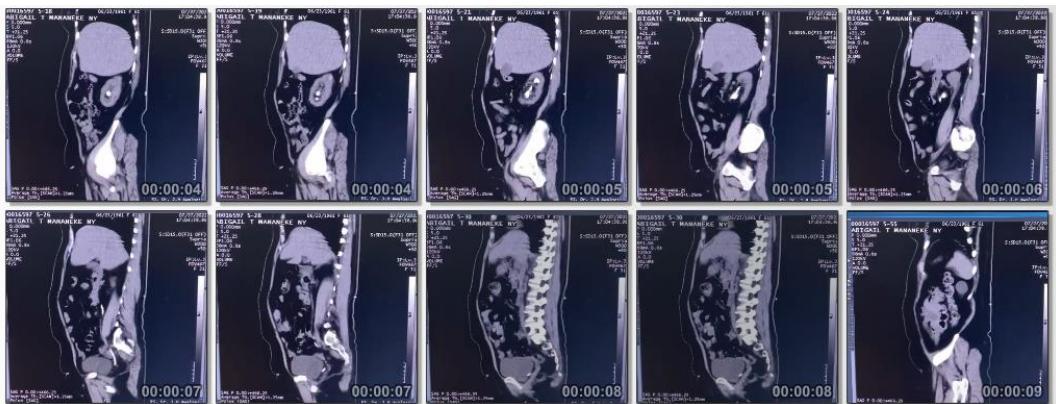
CT-scan sagittal view
